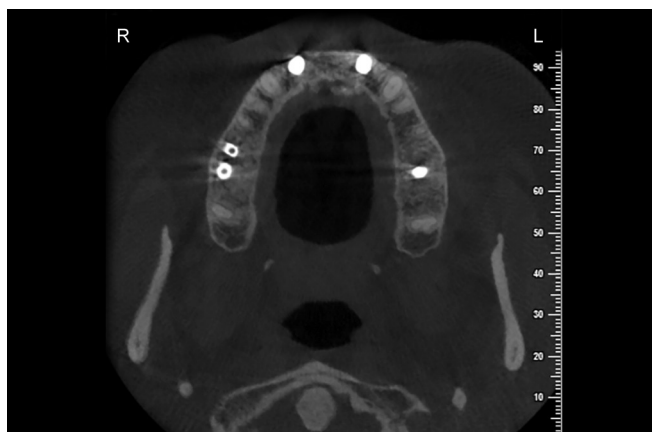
Cone beam computed tomography at the time of uncovering
